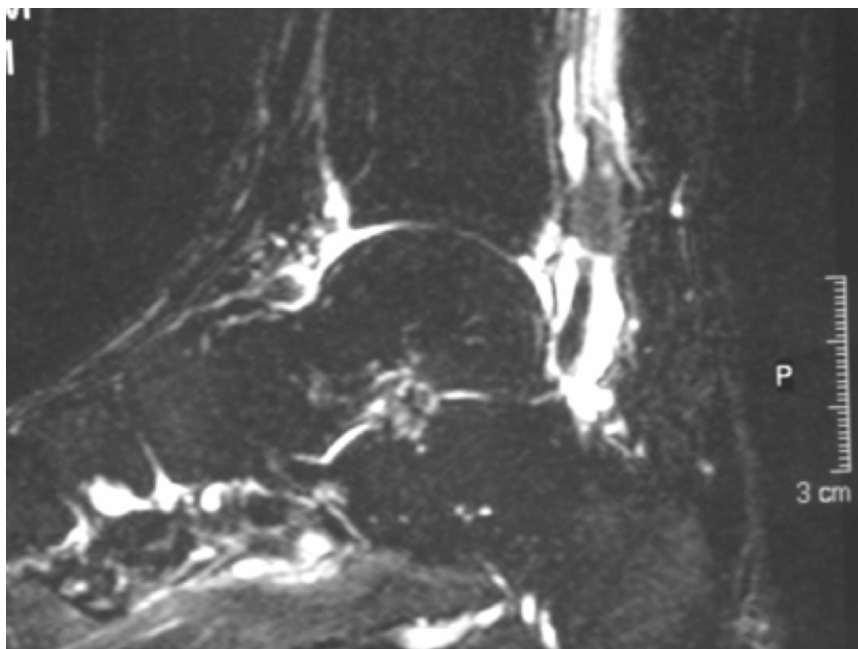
T2-weighted sagittal MRI sequence of a female athlete with flexor hallucis tenosynovitis. Notice the presence of fluid within the sheath
